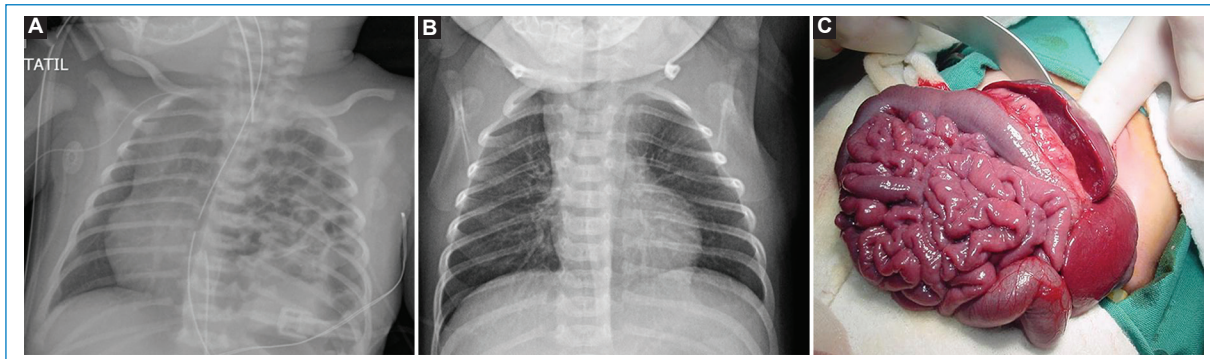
Evolution of Bochdalek hernia. A: postnatal control x-ray, ascent of multiple intestinal loops is observed towards the left pulmonary field, with contralateral displacement of the cardiothymic silhouette. B: late postoperative control X-ray, showing adequate insufflation and symmetrical lung fields, continuous diaphragms and a normally positioned cardiothymic silhouette. C: intraoperative image.
